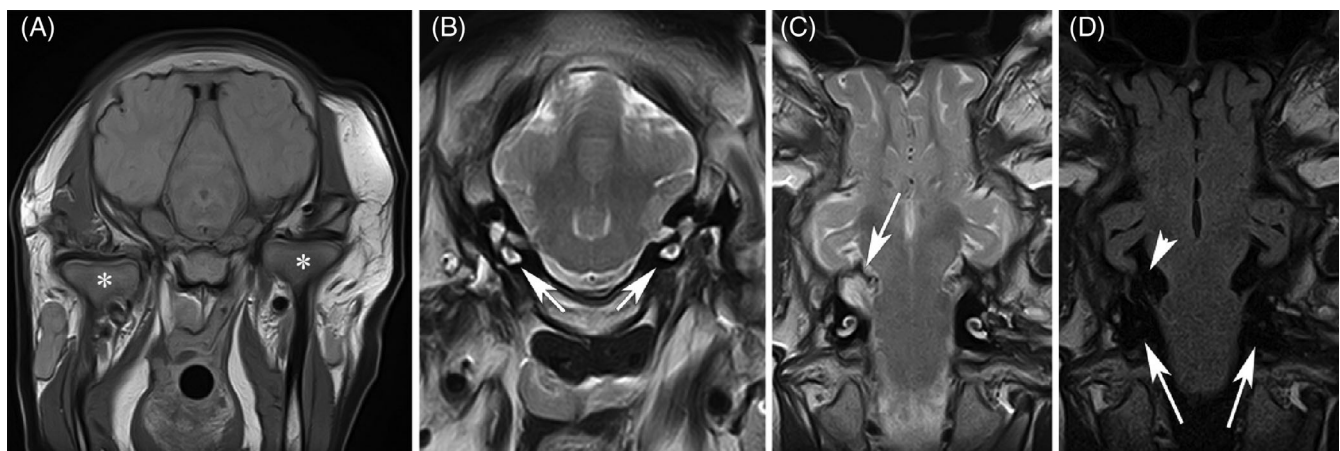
Magnetic resonance imaging of the head in the Romagnola calf with hemifacial microsomia (HFM). (A) Transverse proton density image at the level of the caudal mesencephalon. There is marked asymmetry of the temporomandibular joints (asterisks) and the surrounding soft tissues. (B) Transverse T2-weighted image at the level of the pons. There is a normal hyperintense signal of the perilymph and endolymph in both inner ears (arrows). Note the bilateral agenesis of the tympanic bullae. (C) Dorsal T2-weighted image at the level of the inner ears. An enlargement of the subarachnoidal space (meningocele) is seen on the right side at the level of the pons (arrow). (D) Dorsal fluid-attenuated inversion recovery (FLAIR) image at the same level as (C). The T2-weighted hyperintense signal from the inner ears (long arrows) and cerebrospinal fluid in the meningocele (arrow head) is suppressed
